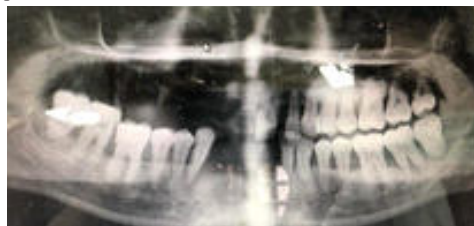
Radiographic (orthopantomogram) view of Pre-treatment
